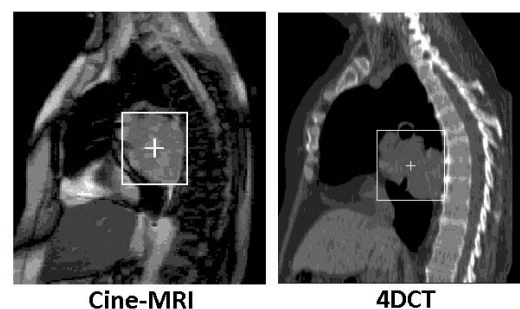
In 4DCT images (right), the sagittal slice that corresponded to the one used in cine-MRI images (left) was visually identified by a radiation oncologist. The boxes and crosshairs indicate the size and position of the tumor.
